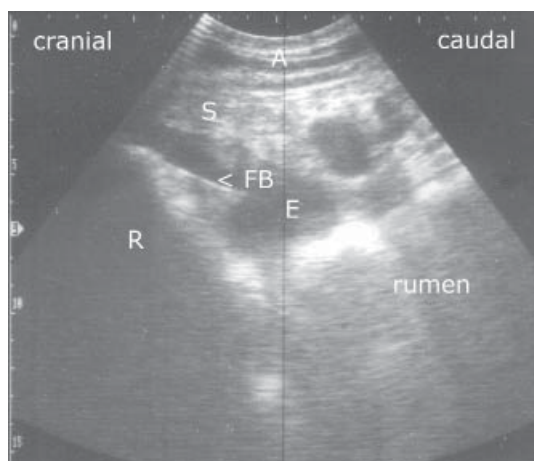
Longitudinal sonogram of a foreign body perforating the caudoventral reticular wall. The linear foreign body is surrounded by hypoechoic fluid. A = abdominal wall, FB = foreign body, E = exudates, S = spleen, R = reticulum.
